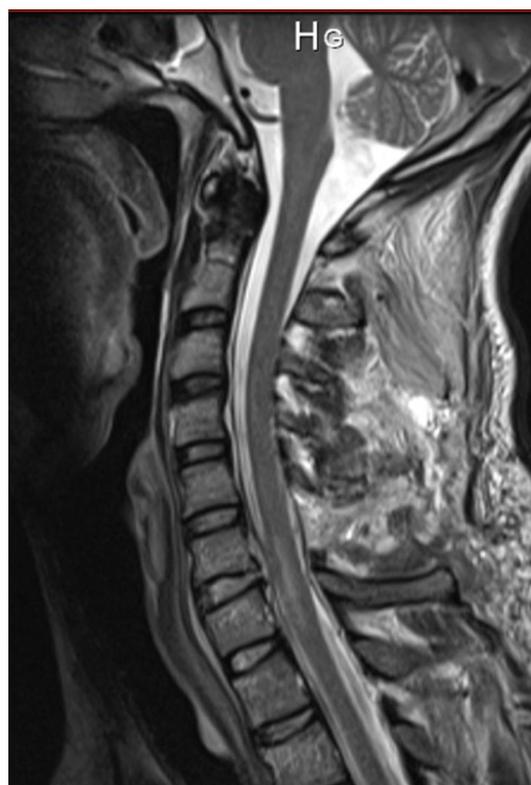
MRI showing an increased cord signal on T2 weighted images with a hematoma behind the C6C7 disc
